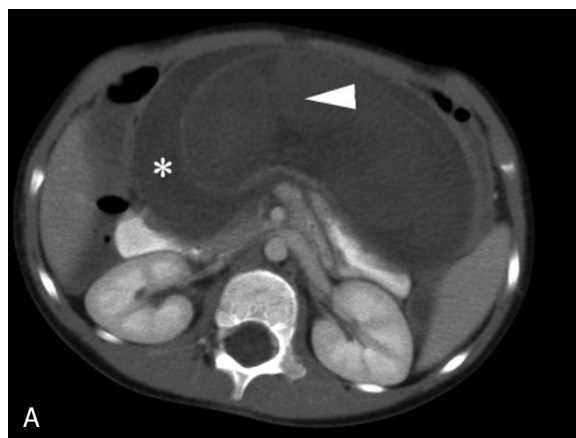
4-year-old boy with small bowel polyps. Contrast enhanced axial CT images demonstrate the jejunojejunal intussusception. A, The intussusceptum (arrow head) is contained within the intussusciens (*). B, Intussuscepted mesenteric fat can also be identified (arrow).
